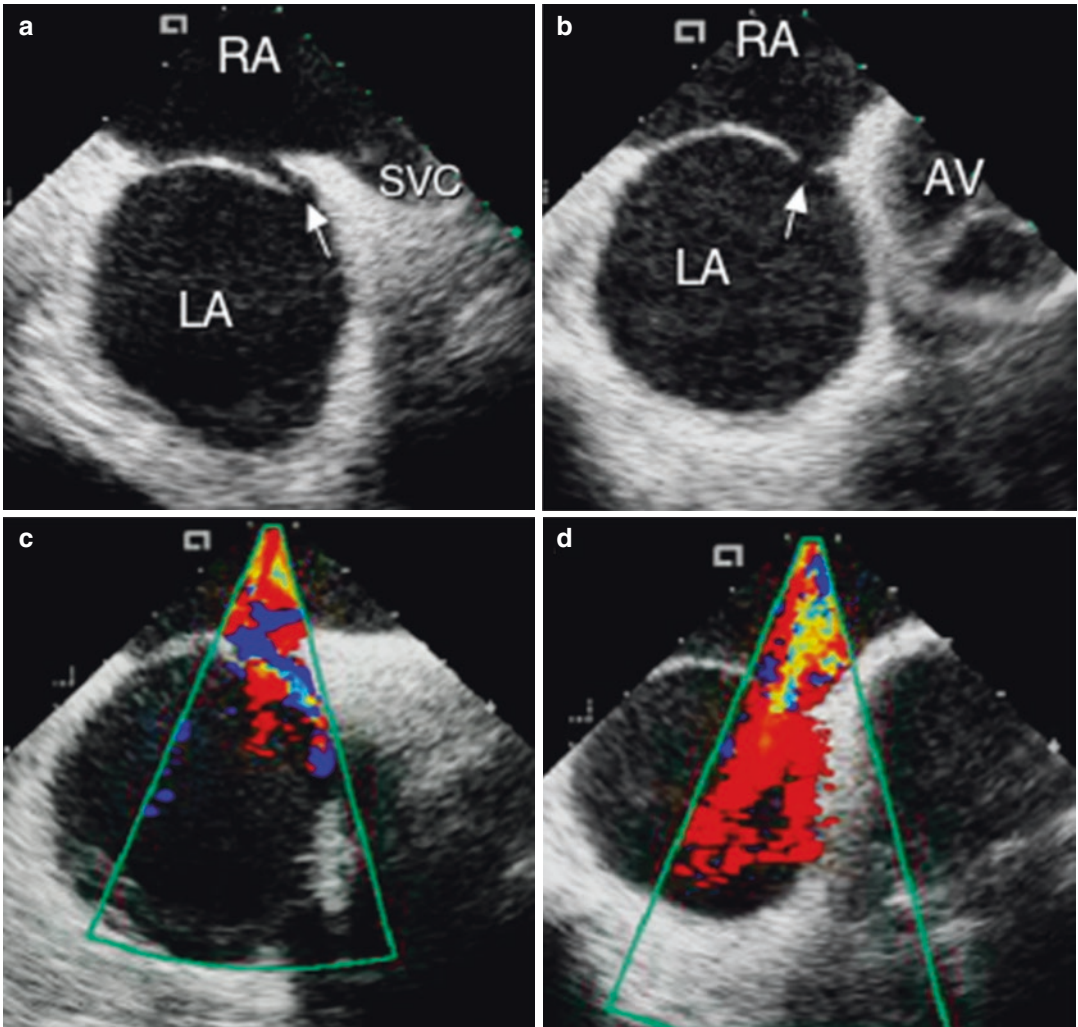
Intracardiac echocardiographic images to assess anatomy of the PFO in a patient who sustained a stroke. (a, b) septal view without and with color Doppler
